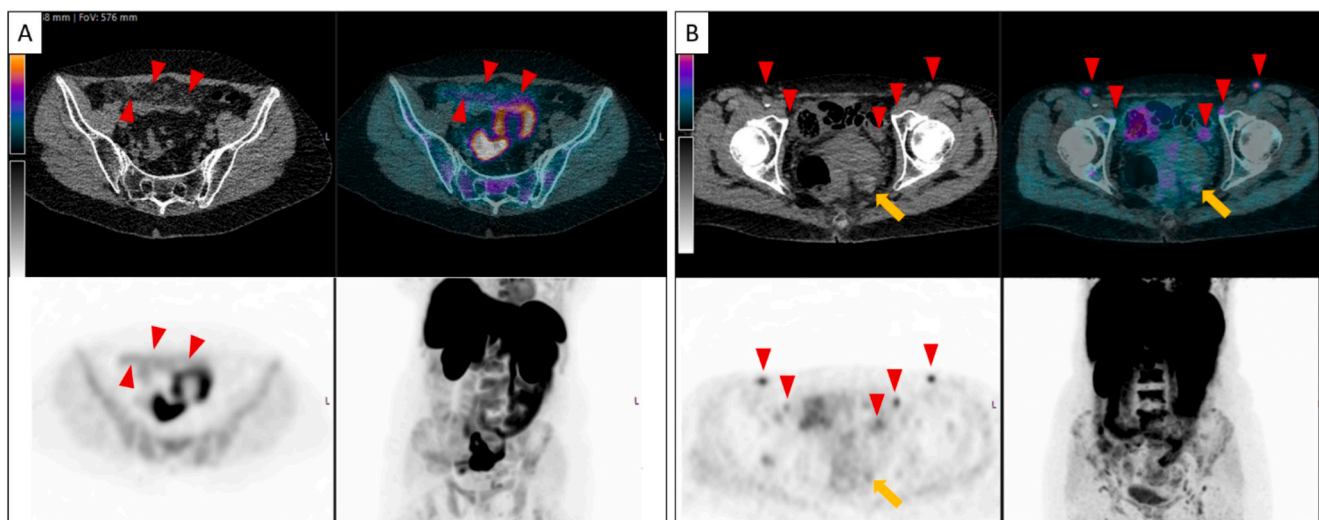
[^{18}F]fluoro-PEG-folate PET/CT: low tracer uptake of EOC metastases (confluent tumor lesions in the omentum) and high uptake in numerous lymph nodes. Two [^{18}F]fluoro-PEG-folate PET/CT scans are presented within each image: a low-dose CT image (left upper corner), PET image (left lower corner), fused PET/CT image (right upper corner), and MIP images of the PET scan (right lower corner). (A) Left PET/CT scan: confluent metastatic disease in the omentum (red arrows) with low tracer accumulation and limited visibility, next to the bowel wall with intense bowel signal (mismatch between PET and CT images). (B) Right PET/CT scan: bilateral inguinal and pelvic nodes (red arrows) with high tracer accumulation. The primary EOC mass on the right behind the uterus (yellow arrows) shows almost no tracer accumulation and some calcifications on non-contrast enhanced CT).
